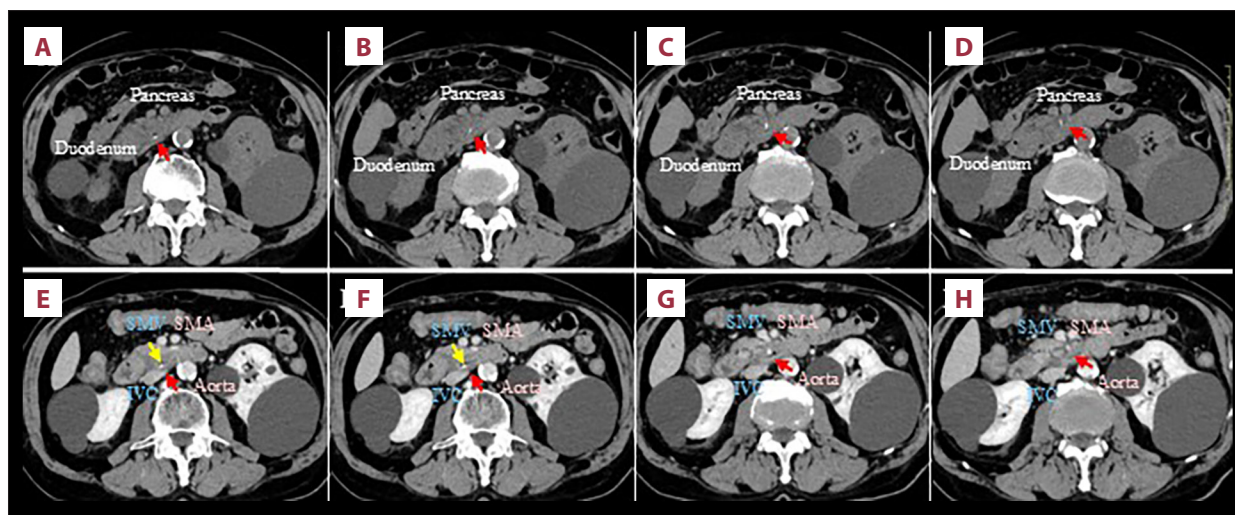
CT findings of a migrated scad bone within the pancreatic uncus. Plain CT detected a straight-shaped foreign body with strong calcification (red arrows) that had migrated into the pancreatic uncus (yellow arrows; A-D). Enhanced CT findings (E-H) showed a duodenal diverticulum in the third portion of the duodenum (yellow arrows) and revealed that the foreign body (red arrows) had fully migrated into the pancreatic parenchyma through the diverticulum. CT, computed tomography; IVC, inferior vena cava; SMA, superior mesenteric artery; SMV, superior mesenteric vein.
